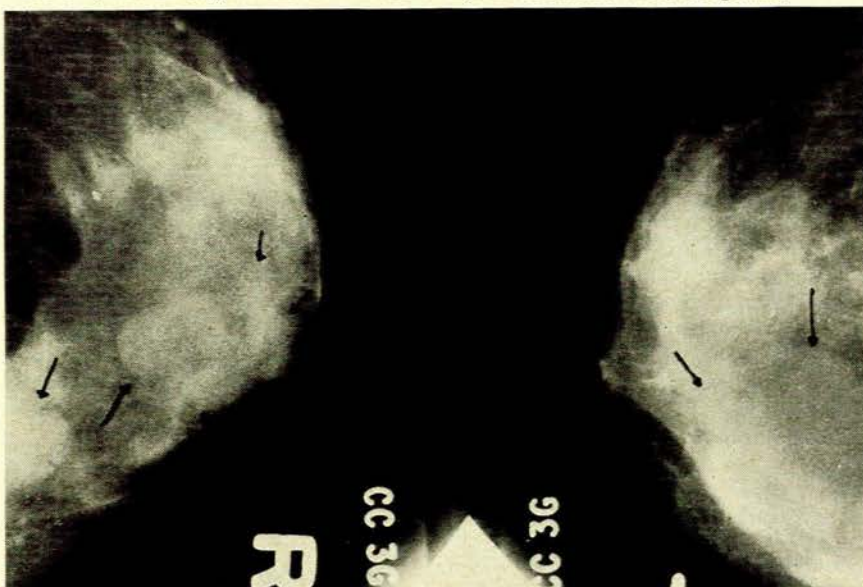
Clinically the patient had a possible mass in the left breast, difficult to define. X-ray showed multiple smooth round and oval masses in both breasts. No primary or secondary evidence of malignancy. Benign multiple cystic mastopathy.
